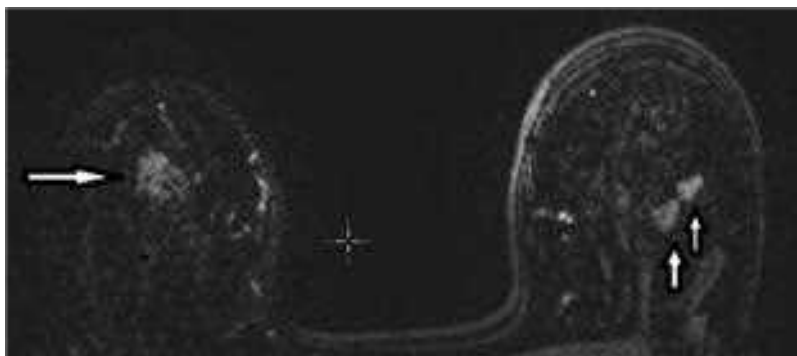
MRI examination revealing contralateral breast cancer in a patient diagnosed with unilateral breast cancer on mammography. (Photo used with permission of Dr. Anne Turnbull, Consultant Radiologist/Director of Breast Screening, Royal Derby Hospital, Derby, UK.)
